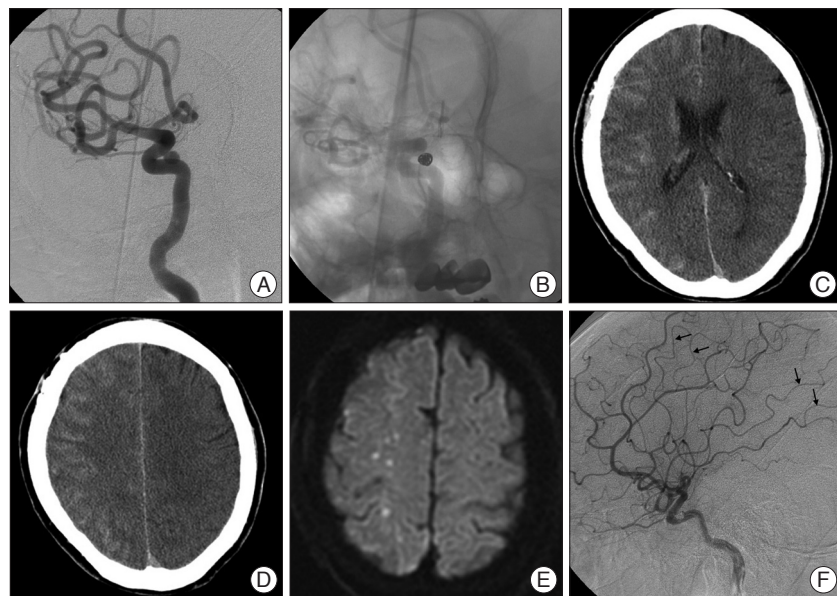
A and B : Procedural angiographic images in case 1. C and D : Immediate postembolization noncontrast CT scan shows diffuse cortical hyperintensity and gyral swelling in the right frontoparietal lobe. E : DWI MRI shows multiple small high signals in the right frontoparietal lobe. F : Angiography revealing diffuse narrowing of frontoparietal cortical branches of the MCA (arrows). CT : computed tomography, DWI : diffusion weighted image, MRI : magnetic resonance imaging.
